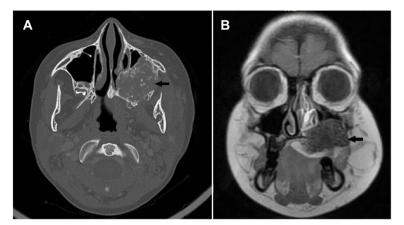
Case 3. a Axial view of CT, thinning and losing of inner and outer cortex. b Coronal view of T1 enhanced MRI. Black arrows showing the lateral border of the granuloma
